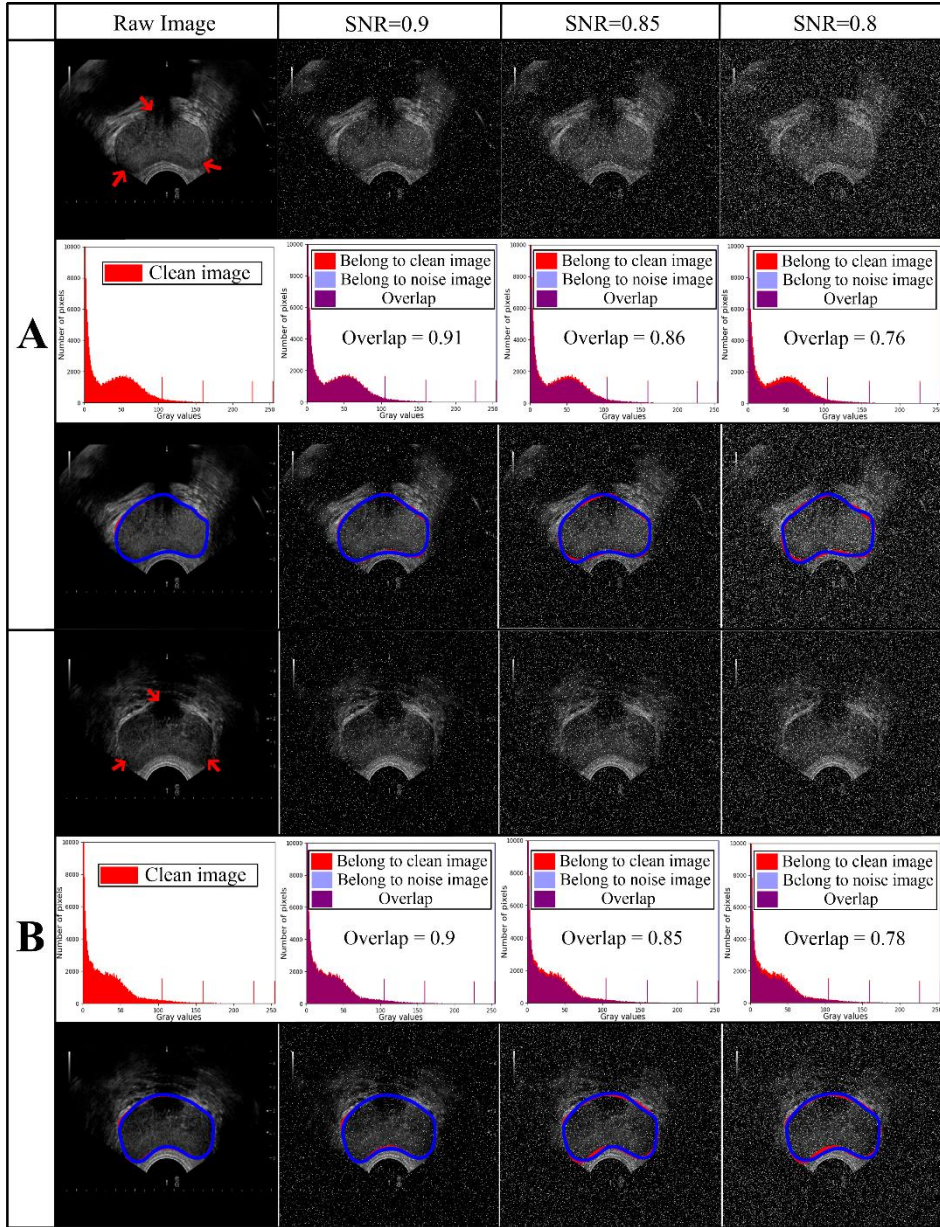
Visualization results of the proposed method at different levels of salt and pepper noise. The red arrow indicates the missing and blurred boundaries of the prostate. In the second and fifth rows, the *overlap* metric is adopted for evaluating the effect of various degrees of noise on original data, and details are shown below: first, the number of pixels for the gray value within [0, 255] in the ultrasound image is calculated. Secondly, the overlap region is shown, where the red and light blue represent the areas that only belong to clean images and noisy images, respectively, and the purple area represents the pixel overlap area between clean and noisy images. Finally, the *overlap* metric is calculated for evaluation.
